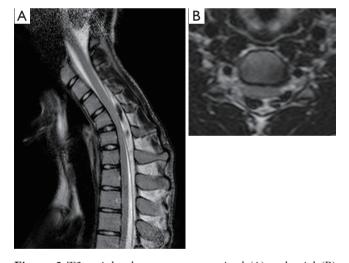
T2-weighted sequence on sagittal (A) and axial (B) planes. Posterior detachment and forward shifting of the dural sac with presence of epidural flow-voids from posterior venous plexus congestion, during neck-flexion (A). Antero-posterior cord flattening is evident on the axial plane (B).
